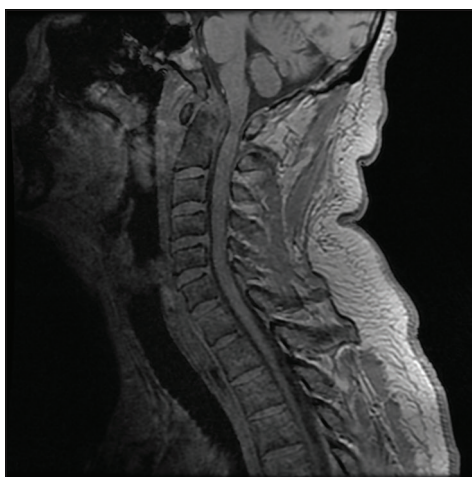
Sagittal T1 magnetic resonance imaging – evidence of a retropharyngeal mass expanding to the C1-C2 complex, yet the C1 anterior arch – C2 dens distance is preserved. The dens are centered without evidence of instability.
